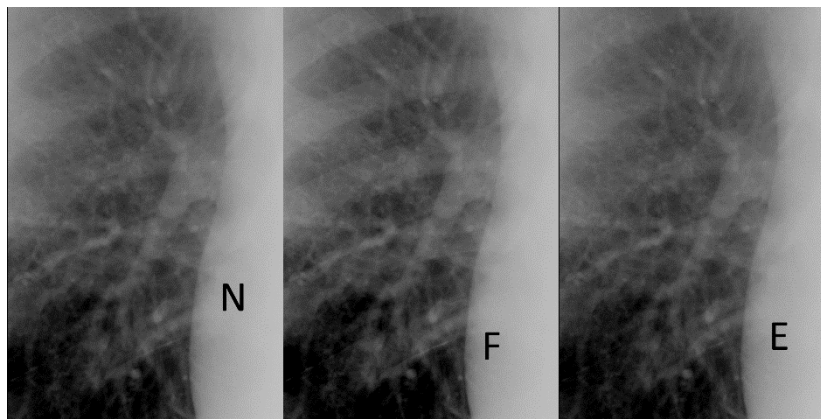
Example of the resulting image for the criterion 3 (Hilum of the lung) for the FC X-ray unit. Segments corresponding to the anatomical region of the hilum were cut from the chest images acquired on a different tube voltage (60, 90 and 120 kV), shuffled and merged. The letters (N, F, E) encode the tube voltage.
